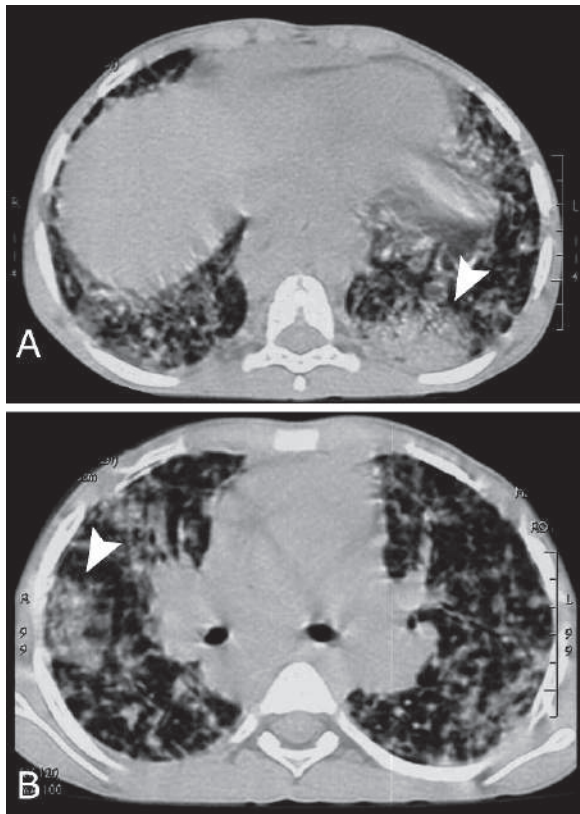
Axial lung window HRCT of the lungs show bilateral patchy lung consolidation with a mass of consolidation located at the subpleural, peripheral, posterior lung lobe (arrowhead in a) and the right subpleural area in the right middle lobe (arrowhead in b) due to cryptogenic organizing pneumonia
